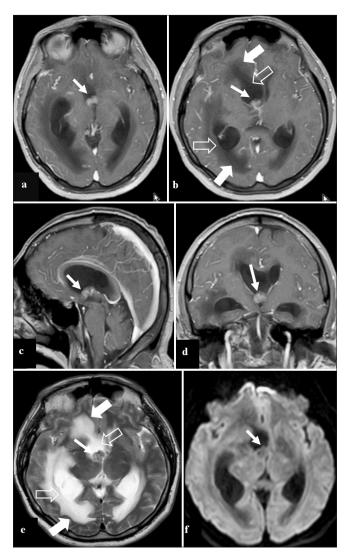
Contrast-enhanced brain magnetic resonance imaging preoperative. (a) Contrast-enhanced T1 image in the axial section that shows a mass in the right frontal horn (arrow), which seems to obstruct the ipsilateral foramen of Monro. (b) Contrast-enhanced T1 image in axial view, 5 mm above image a, which shows the same tumor (thin arrow); furthermore, it shows ventricular dilation (empty arrow) with transependymal edema (thick arrow). (c) Contrast-enhanced T1 image in sagittal view shows the tumor in the right foramen of Monro (arrow). (d) Contrast-enhanced T1 image in coronal view, which evidences the tumor in the lower edge of the right frontal horn (arrow) close to the ipsilateral foramen of Monro. (e) T2 image shows a tumor in the right frontal horn, isointense (arrow thin), associated with ventricular dilation (empty arrow) and transependymal edema (thick arrow). (f) Diffusion-weighted image shows no restriction of the tumor of the right frontal horn (arrow).
